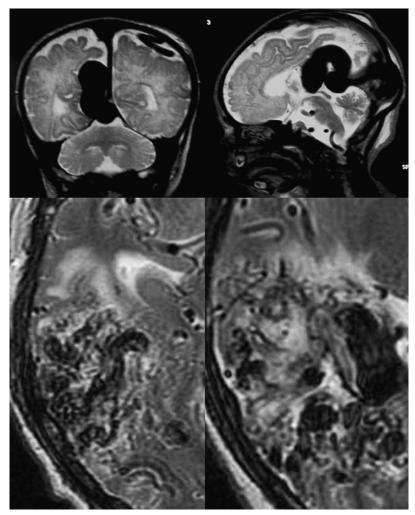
Whether a nidal or a fistulous transition between arteries and veins is present can in most instances be seen from the MRI alone. This factor has major implications on the pathophysiology and on the choice of treatment modalities.
